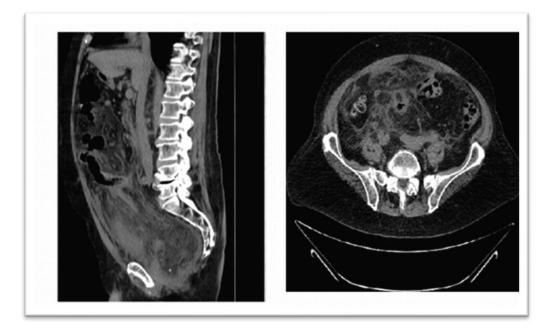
CT abdomen and pelvic shows misty mesentery sign
